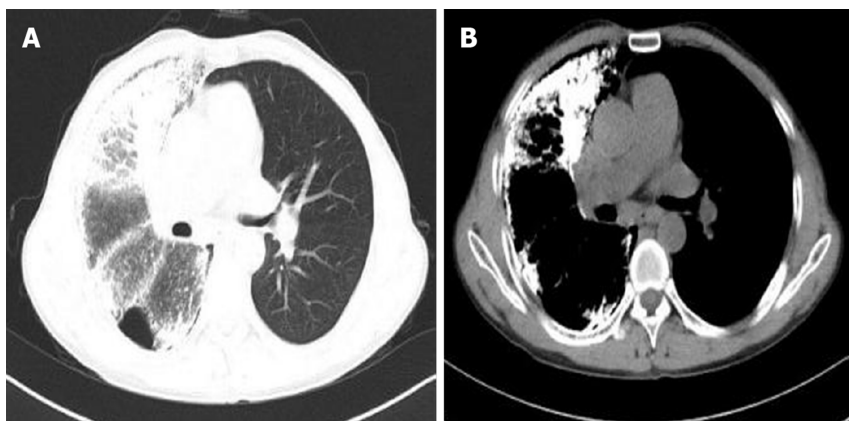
Postoperative imaging. A and B: Chest computed tomography images acquired at the last follow-up visit in April 2019 indicate a good recovery.
